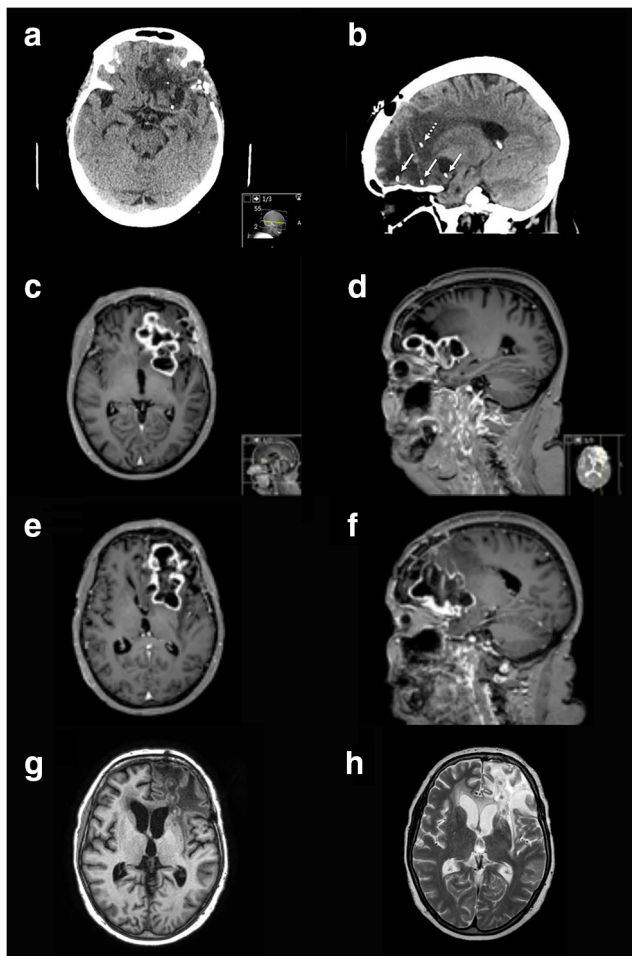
A–H Patient 7 with three catheters for treatment and one catheter in BAT. A and B The tips of the catheters are demonstrated on a non-enhanced CT investigation. Solid arrows = tumor catheters, dashed arrow = BAT catheter. C and D Before treatment. E and F Progressive necrosis after 12 days of treatment. G and H Edema reaction along the catheters outside of the tumor and proximal of the semipermeable membranes after 12 days of treatment
